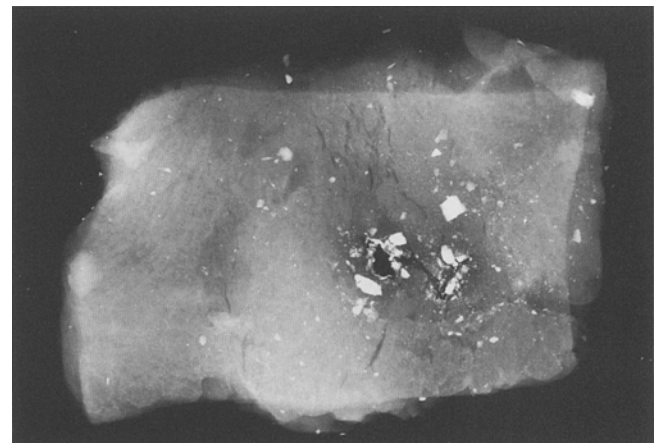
Roofing tile particle in the depth of a wound (low energy X-ray imaging)
